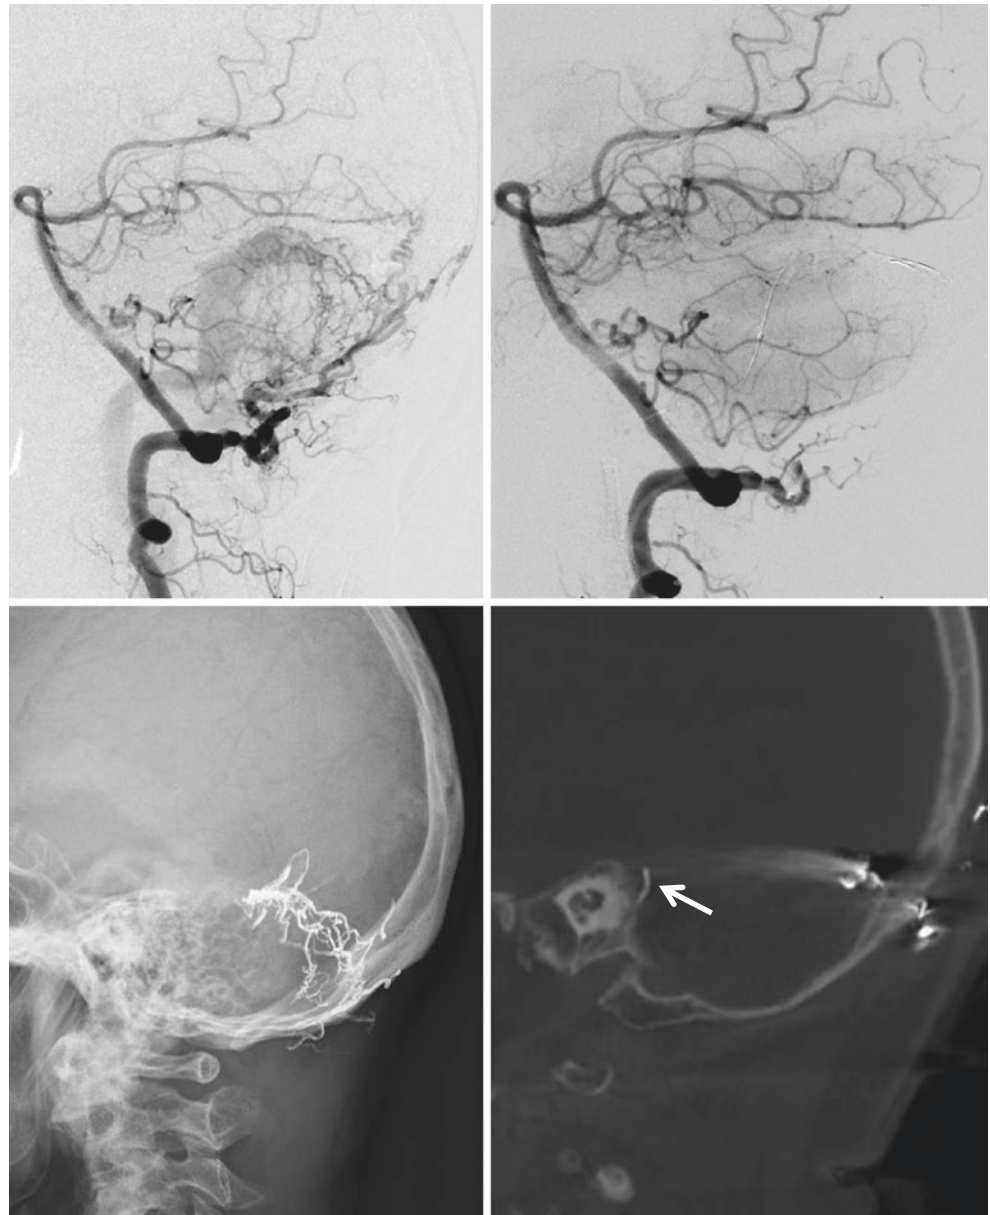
A case with Borden type-I dAVF involving the transverse-sigmoid sinus. The shunt was obliterated with Onyx injection from the distal occipital artery arising from the vertebral artery. A balloon catheter was inflated in the involved sinus to prevent Onyx migration to the sinus side. (a) Preoperative vertebral angiogram. (b) Postoperative vertebral angiogram indicating complete obliteration of the shunt. (c) Postoperative craniogram showing the Onyx cast. (d) Postoperative cone beam CT indicating Onyx migration to the tinny petrosal vein (arrow) via the superior petrosal sinus
